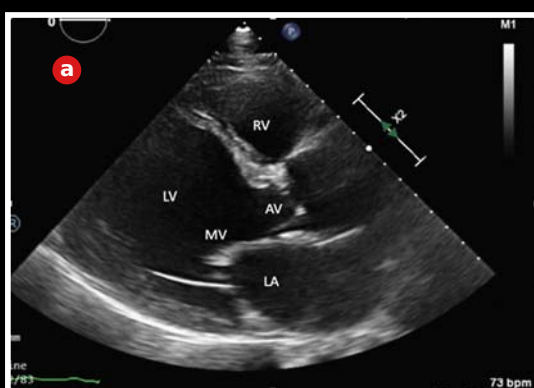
Transthoracic echocardiography (TTE), parasternal long axis (PLAX) - dilated LV (a); severe aortic regurgitation with eccentric jet occupying the entire LVOT (b); severe mitral regurgitation with jet through the body of the anterior mitral cusp (c).
